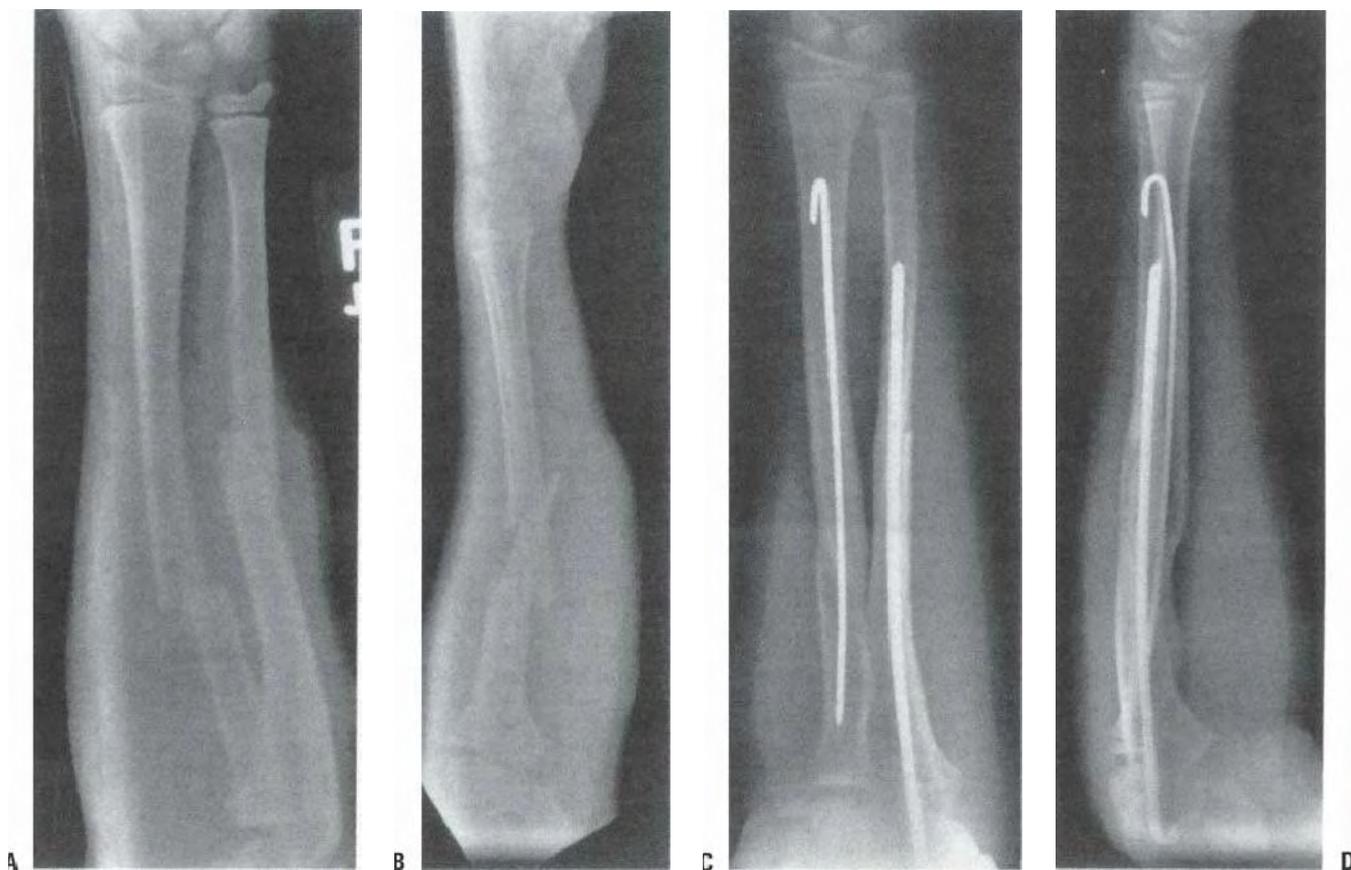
The AP (A) and lateral (B) radiographs of a 10-year-old boy who sustained a grade I open fracture of the radius and ulna. The proximal fragment of the radius had punctured the skin on the volar aspect of the forearm. After exploration, irrigation, and debridement, it was not possible to secure a stable reduction. The ulna and then the radius were treated with IM rodding. The radiographs 4 months after surgery (C, D) show the healing and the position of the rods. A more flexible Steinmann pin was used in the radius. This makes it easier to pass, is less likely to alter the radial bow, and provides adequate alignment.
